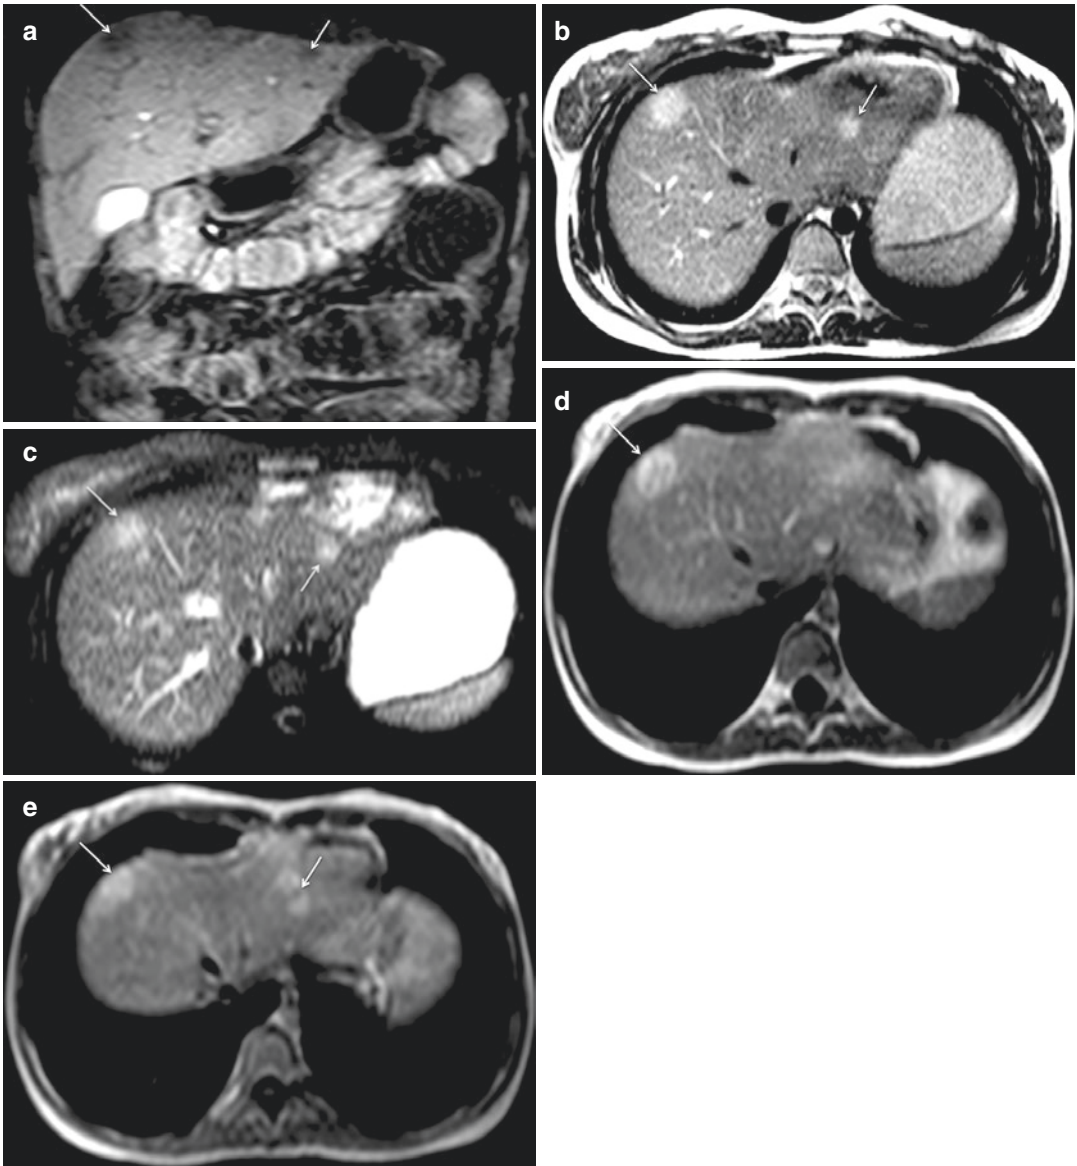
Pyogenic liver abscesses in a febrile patient with Crohn's disease. Coronal T1-weighted fat-saturated GE image (a). Axial T2-w HASTE (b) and axial T2-w fat-saturated HASTE (c) scans. Axial T1-weighted fat-saturated GE images, obtained after i.v. administration of Gadolinium (d, e). MR shows two peripheral hepatic abscesses (arrows) hypointense on T1-weighted image
